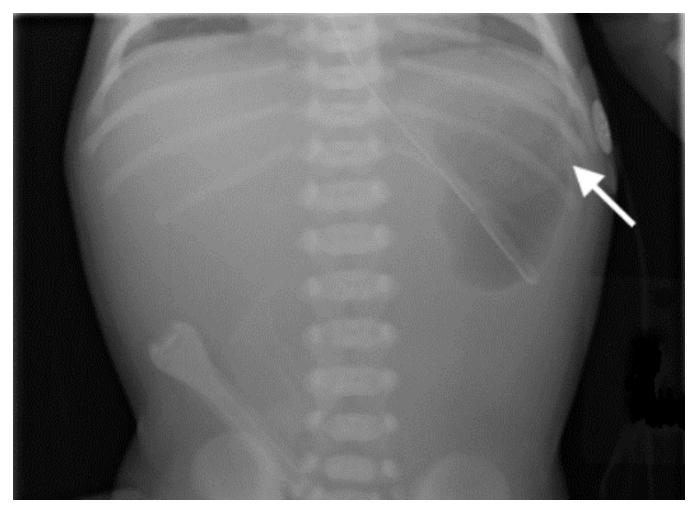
Radiograph of a 36-week gestational-age, one-day-old neonate with EB-PA. Note the single gastric bubble (white arrow).
